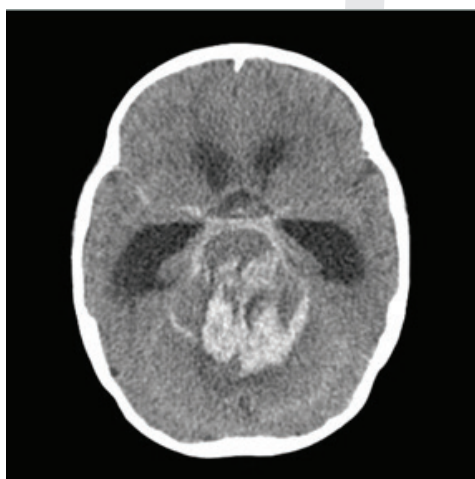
Computed tomography scan of the brain after convulsion shows bleeding around brainstem associated with subarachnoid haemorrhage and hydrocephalus¹¹
